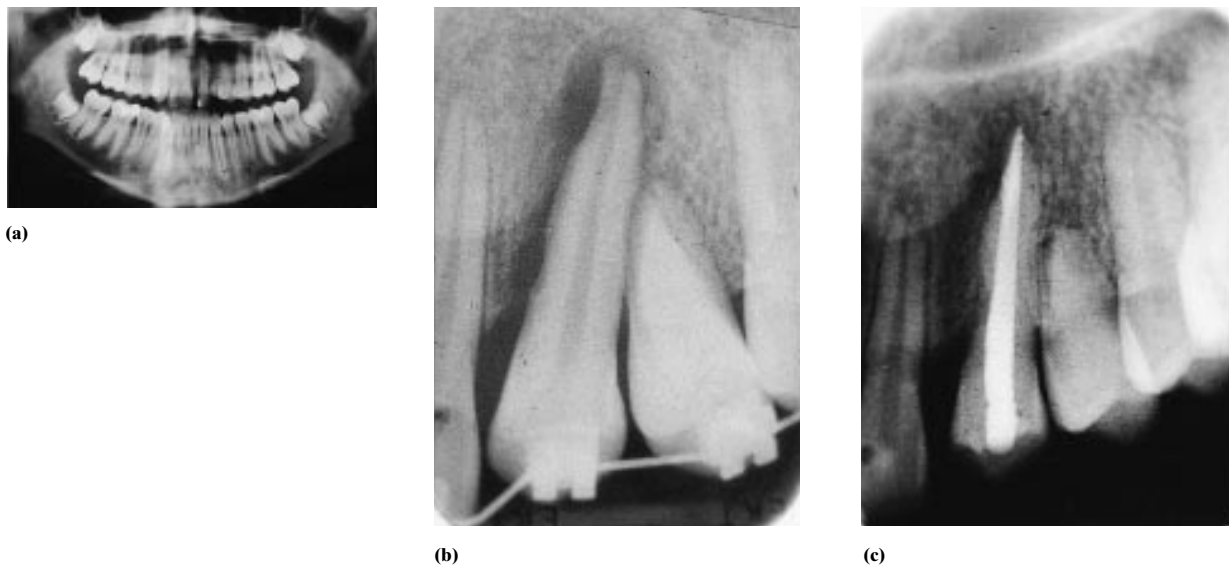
(a–c) (a) Radiograph of a 15-year-old boy with a Class I malocclusion and absent $\underline{13}$. Fixed appliances were used to move the $\underline{12}$ mesially into the $\underline{11}$ region and a premolar with a mature apex from the crowded lower arch was transplanted into the $\underline{12}$ region. (b) There was a delay in carrying out the endodontic treatment resulting in root resorption. (c) The resorptive process was stabilized once the endodontic treatment was completed and this radiograph taken 1 year after root treatment revealed no evidence of further root resorption. (Courtesy of P A Cook, Leeds Dental Institute.)
